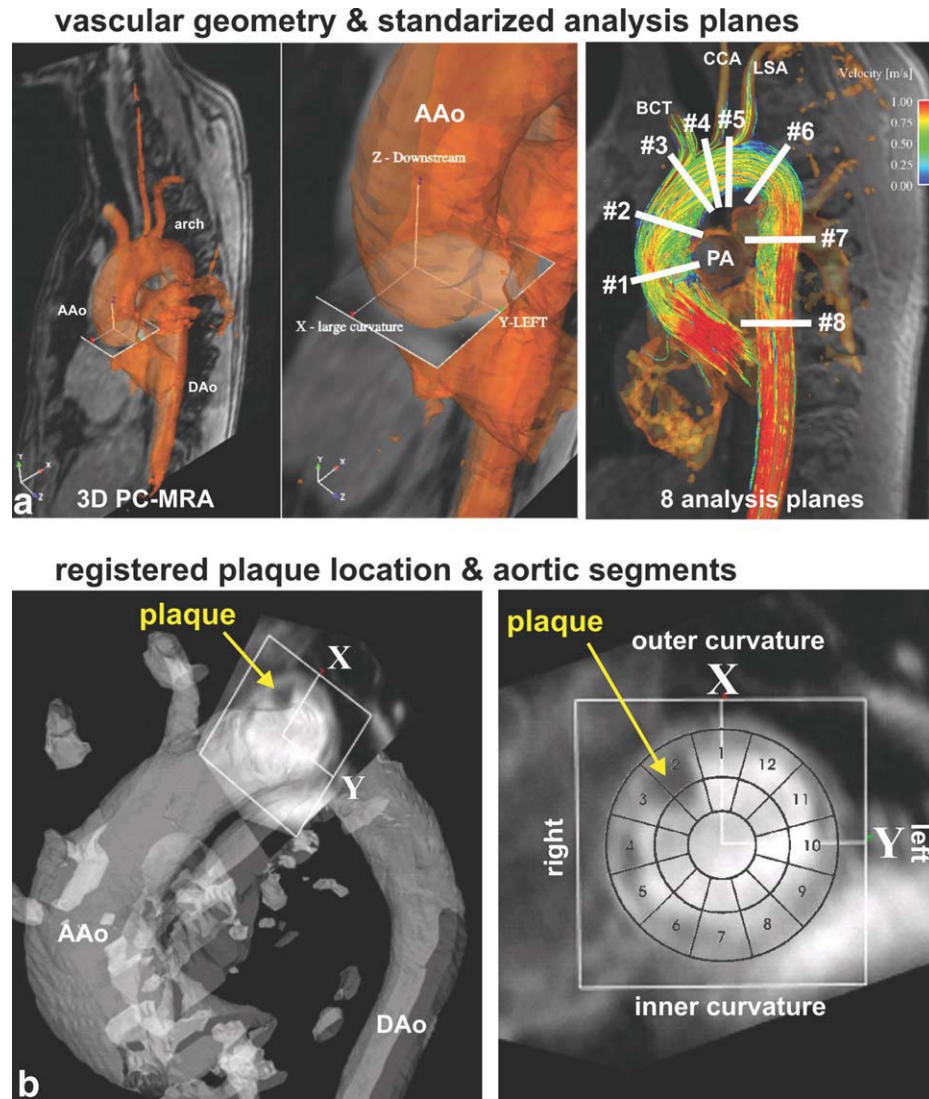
a: Consistent analysis plane orientation and locations for WSS quantification based on the 3D phase-contrast MR angiography geometry. The x-axis was always directed to the outer curvature of the aorta, the y-axis perpendicularly to left aortic wall, and the z-axis pointed downstream. Plane #1 is located in the ascending aorta at the level of the pulmonary artery (PA), plane #3 immediately proximal to the outlet of the brachiocephalic trunk (BCT), and plane #2 in between these planes. Plane #4 is positioned between the outlet of the BCT and the left common carotid artery (CCA), plane #5 between the outlet of the CCA and the left subclavian artery (LSA). Plane #6 lies in the descending aorta (DAo) in the center of the distal aortic arch, #7 at the beginning of the straight segment of the DAo and plane #8 in the distal DAo at the level of the aortic valve. b: Definition of aortic segments affected by plaque thickness ≥ 4 mm by image fusion of the detected plaque (large thrombus of the proximal descending aorta, yellow arrow) and the flow-sensitive 4D MRI data. Analysis plane and plaque plane orientation were carefully matched using x and y orientation as precise landmarks. In this case, segments 2 and 3 were affected by plaque thickness ≥ 4 mm. AAo = ascending aorta.
